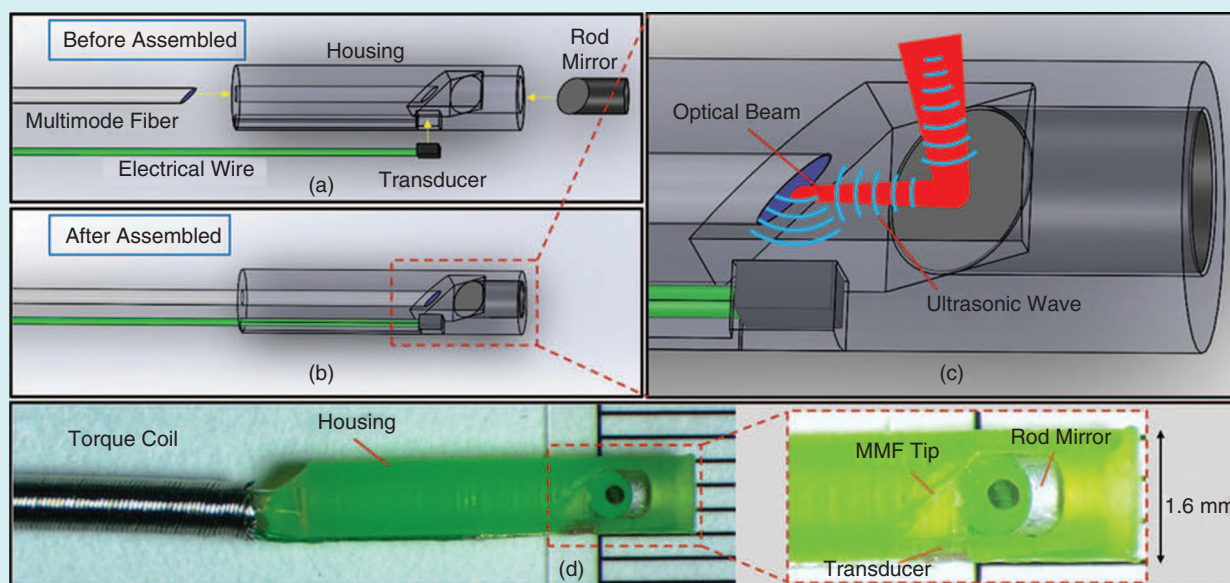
A new catheter probe, developed by researchers at Purdue University, the Indiana University School of Medicine, and the Shanghai Institute of Optics and Fine Mechanics, can generate three-dimensional images of artery interiors, potentially helping physicians to diagnose plaque on the verge of rupturing. (a) The main components of the collinear catheter before assembly. (b) The assembled catheter probe. (c) A zoomed-in view of the catheter tip shows the collinear overlap between optical and ultrasonic waves. (d) The fabricated 1.6-mm catheter probe and the detailed structure of the catheter tip (inset).
